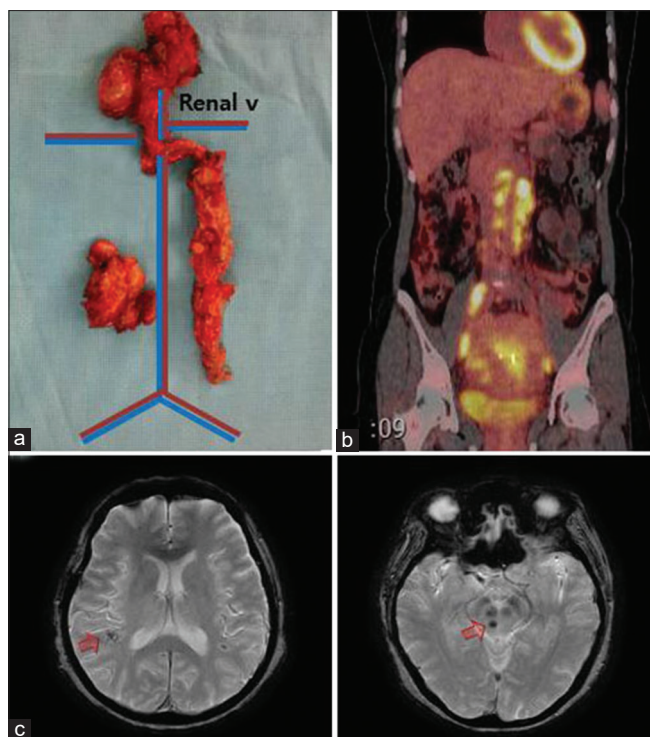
Aggressive clinical course of SACC with p53 expression: Operative findings and images. Resected lymph nodes (a) and PET-CT image (b) showing extensive lymphadenopathy throughout the pelvis and abdomen (case 3). Enhancing masses in the temporal lobe and pons were revealed (c) (case 5). SACC = Serous adenocarcinoma of the uterine cervix; PET-CT = Positron emission tomography-computed tomography
